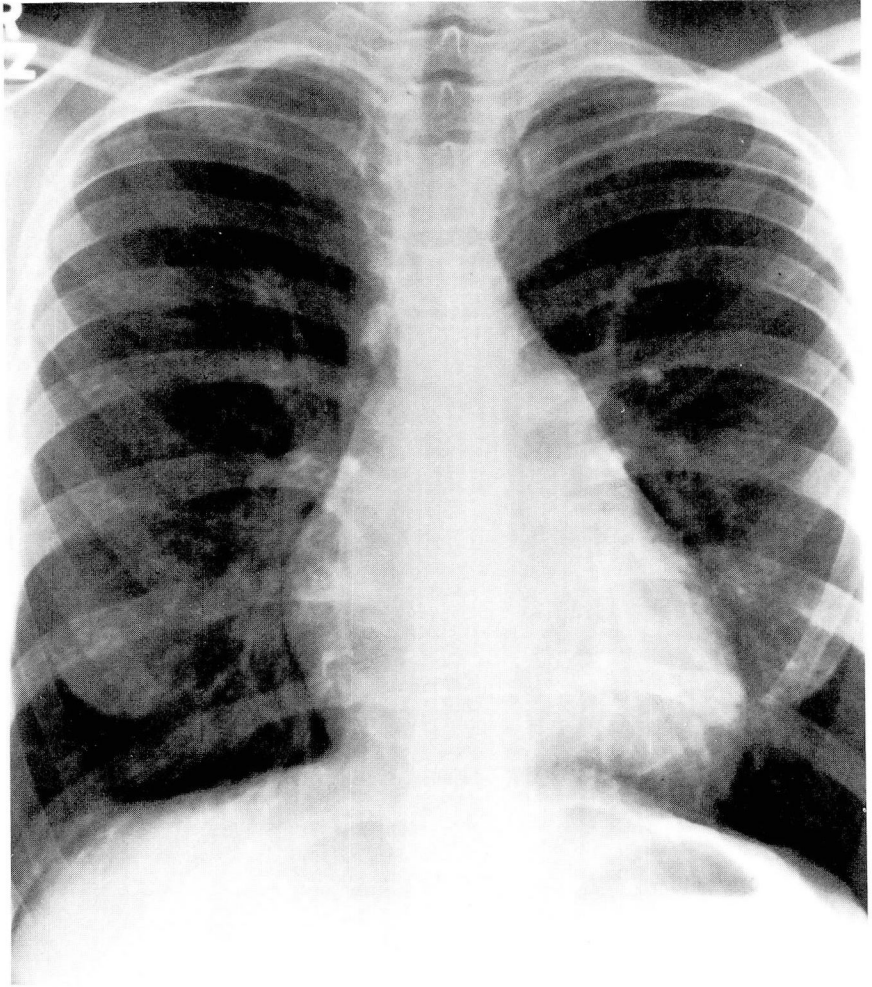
Postoperative follow-up chest roentgenogram at 6 months.
